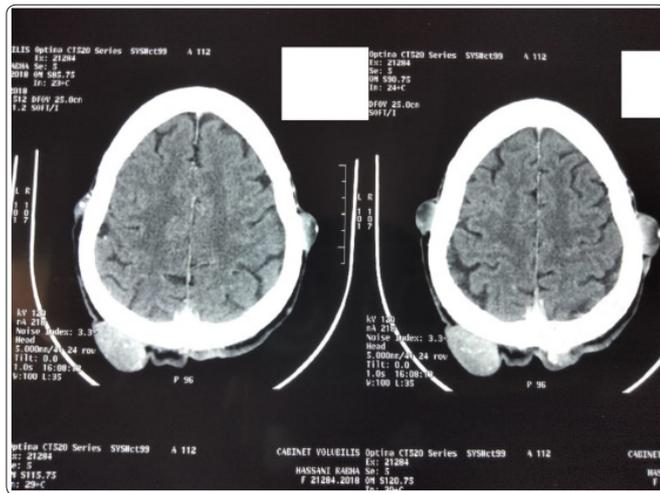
Axial contrast-enhanced CT scan showing the other benign trichilemmal cysts.
